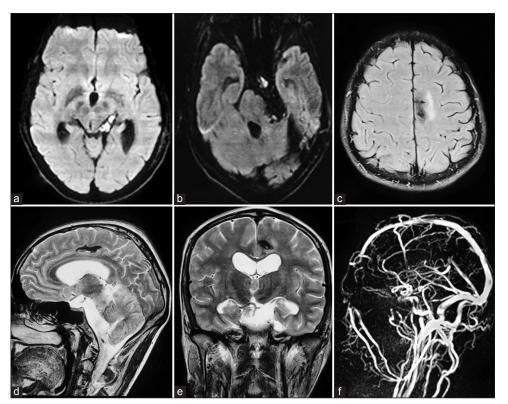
(a-f) At two months follow-up, magnetic resonance imaging of the brain suggestive of near total excision of the epidermoid cyst with resolving left parafalcine frontoparietal bleed. Magnetic resonance venography was suggestive of a patent superior sagittal sinus.
